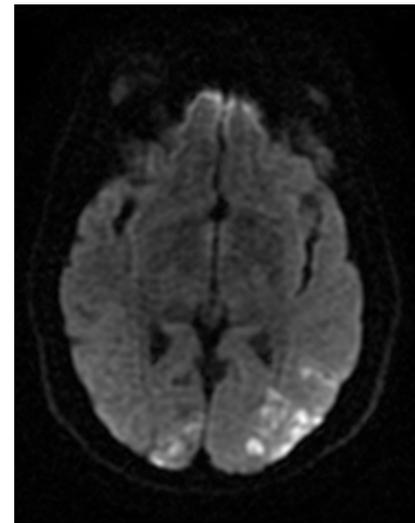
Axial DWI image of brain MRI shows patchy restricted diffusion in left temporal occipital and right occipital lobe
